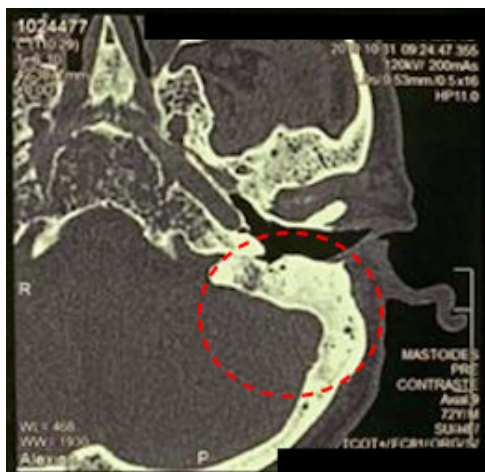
Axial computed tomography of the left mastoid showing hypoattenuating content and sclerosis of the internal cortical bone.
